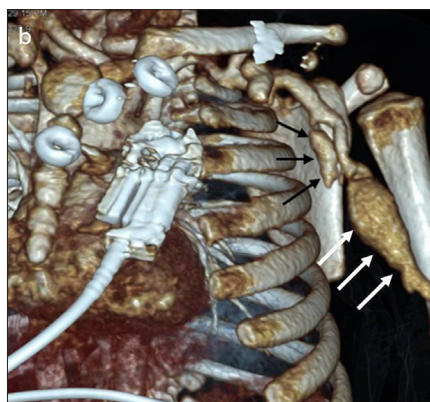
a, b. Left axillary artery aneurysms without thromboses in a 5-year-old male patient with peripheral gangrenous findings and fever. Coronal CT angiogram (a) demonstrates left axillary (black arrow) and brachial (white arrow) artery aneurysms without thromboses. Anterior 3D volume-rendered CT image (b) shows left axillary (black arrows) and brachial (white arrows) artery aneurysms.
